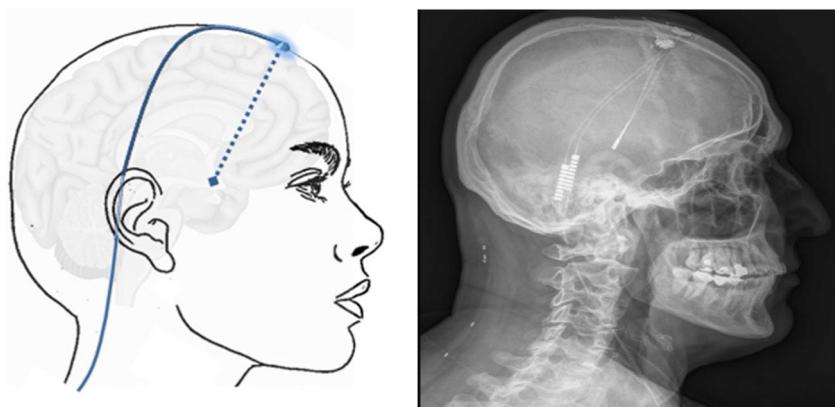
Left: electrodes implanted in the hypothalamus (blue dashed arrow) through a frontal burr hole with a subcutaneous lead. Right: postoperative CT image showing the electrode implanted in the hypothalamus in a patient with left-sided chronic refractory cluster headache.
